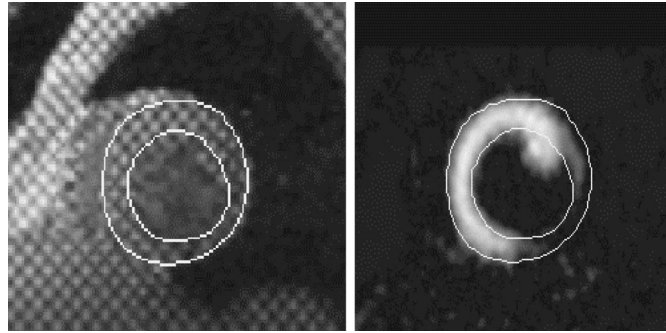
Comparison between an image of the myocardium extracted from the PET data (right image) and an anatomical MR image of the heart (left image). The LV contours drawn on the MR image (on the left) have been superimposed on the PET image. One can notice the good correspondence in the thickness and shape of the LV.
